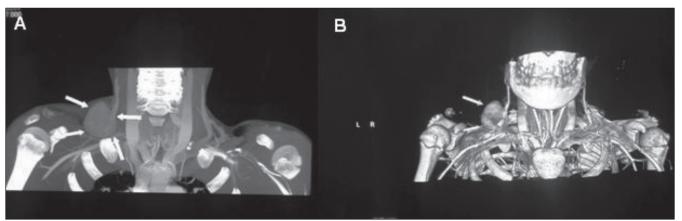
Multi-slice computed tomography depicts right external jugulary vein aneurysm (arrows).
